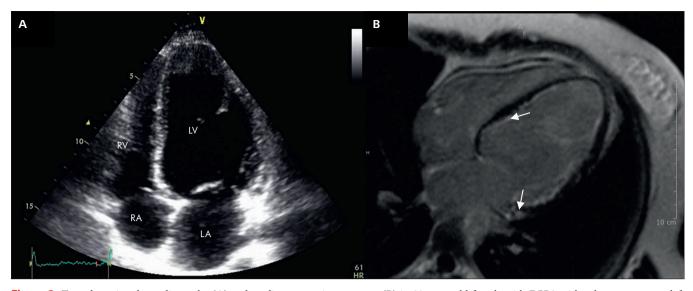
Transthoracic echocardiography (A) and cardiac magnetic resonance (B) in 20 years old female with EGPA with subsequent severe left ventricular systolic wall (arrows). LV – left ventricle, RV – right ventricle, LA – left atrium, RA – right atrium
